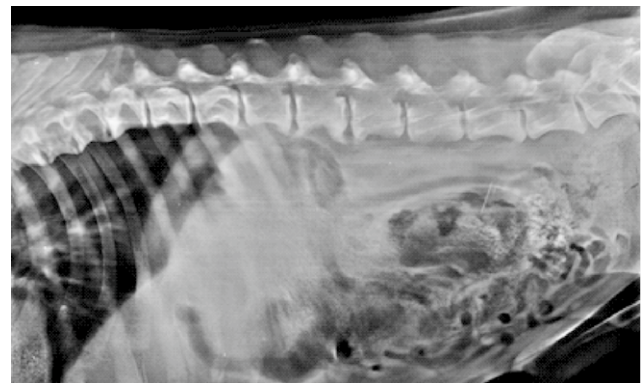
Lateral radiograph of Case-2 demonstrating Spondylosis deformans, Grade 2 (white arrow)-bony spur protruding beyond the caudal/cranial edge of the vertebral border of L1-L3 and T8-T11.
